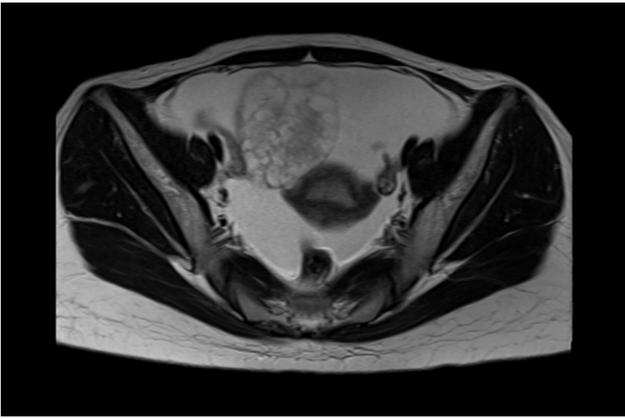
Abdominopelvic CT scan shows a multilocular cystic component and solid areas arising from the right ovary with large amounts of ascites.
